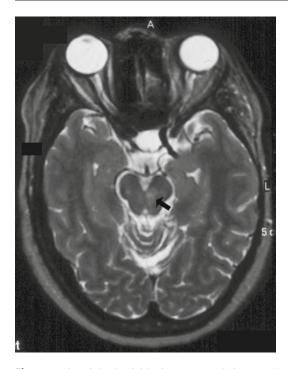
T2-weighted axial brain MRI reveals increased T2 signal in the left ventral midbrain in a patient with ischemic Weber's syndrome with right hemiparesis and a left third nerve palsy
